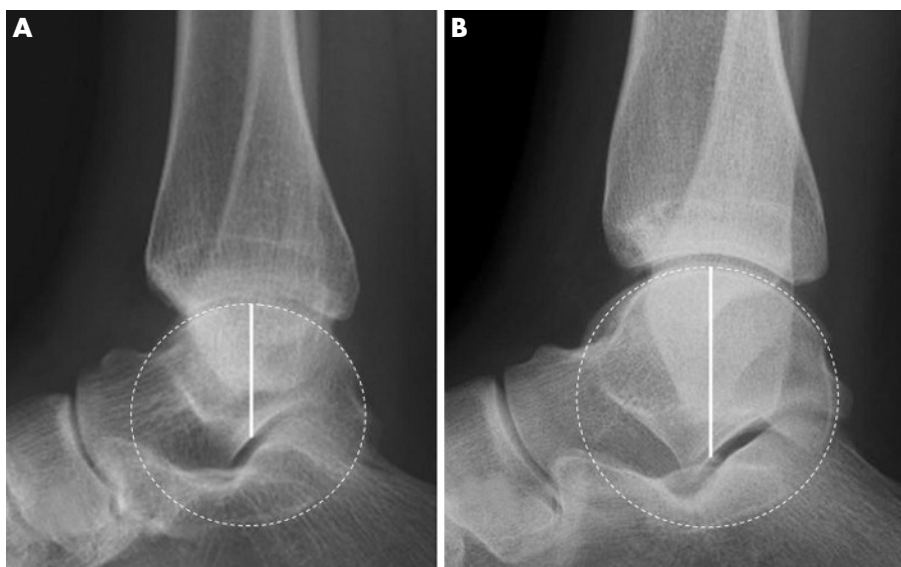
Lateral x rays of the ankle joint with different talar heights. Radiographs of (A) a stable ankle with a flat talus and (B) an unstable ankle with increased height of the talus.
